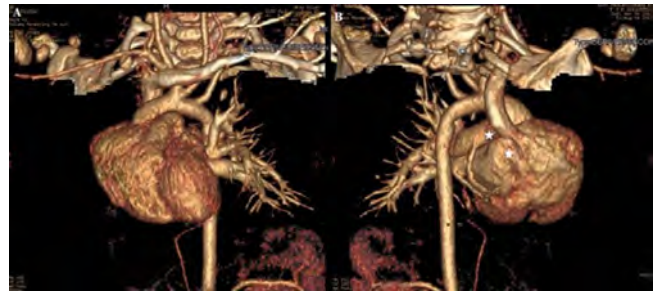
Anterior (A) and posterior (B) view of pulmonary vascular structures. 3D reconstruction of CT angiography show absence of pulmonary artery and veins on the right side (asteriks).
